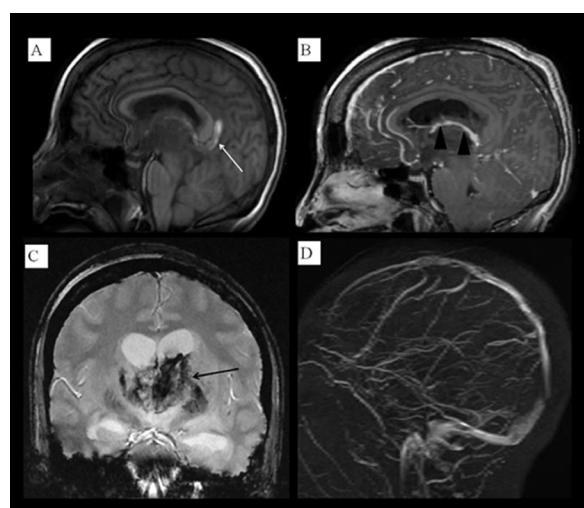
MRI images showing (A) sagittal reconstruction of FSPGR pre Gadolinium, (B) sagittal reconstruction of maximum intensity projection (MIP) FSPGR post Gadolinium, (C) coronal GRE and (D) MRV using TOF reconstruction. Filling defects are seen within the great vein of Galen and internal cerebral veins in FSPGR sequence post Gadolinium administration (black arrow head) and hyperintense signal on T1W pre Gadolinium (white arrow) in keeping with venous thrombosis. GRE image demonstrates areas of blooming artefact in both thalami consistent with haemorrhagic venous infarction (black arrow). MRV TOF showed flow void in the internal cerebral, great vein of Galen and straight sinuses.
